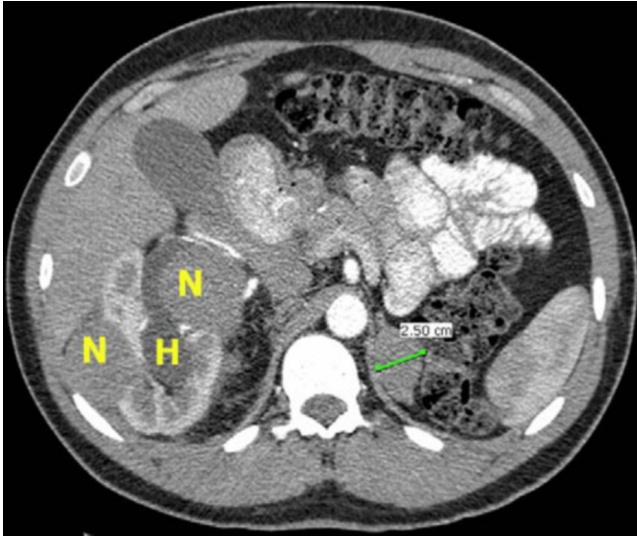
32-year-old male with multifocal renal carcinoid and thyroid metastases. Contrast-enhanced axial CT shows multiple enhancing nodules (N) within the right moiety, mild right hydronephrosis (H) and a 2.5 cm left adrenal mass.
